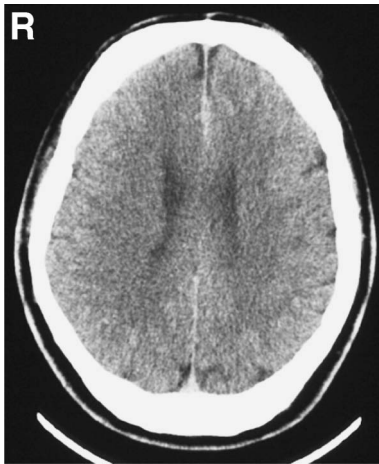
Computed tomography scan showing subarachnoid hemorrhage localized in the interhemispheric fissure.
